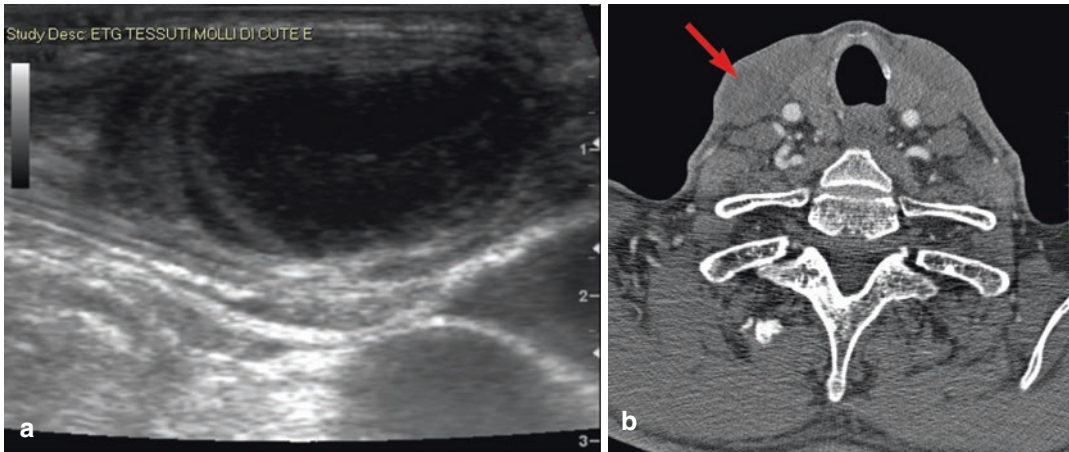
Hematoma of the sternocleidomastoid muscle. The swelling at the base of the neck was evident in the ultrasound and showed an uneven appearance (a). A CT-angiography was then conducted to exclude active bleeding; the lesion was visible with the CT (b), although
